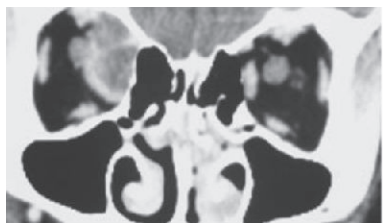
CT scan (coronal view) showing a superior/ medial orbital subperiosteal abscess on the right side
